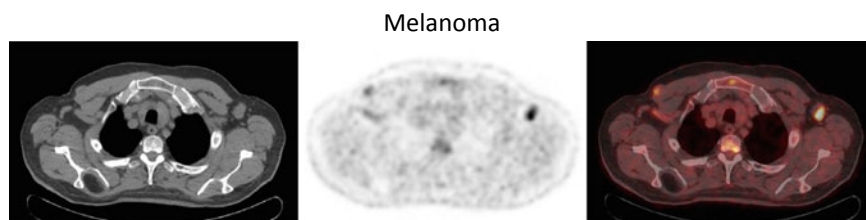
78-year old male patient with melanoma of the left shoulder, pT4b, corresponding to AJCC stage IIC, referred to FDG PET/CT for initial staging after primary resection without sentinel lymph node biopsy. FDG PET/CT showed an FDG-positive lymph node metastasis in the left axilla and revealed another suspicious FDG-positive nodule adjacent to the right musculus pectoralis major; (A1) CT-Scan, (B1) PET scan, (C1) PET/CT fused images
